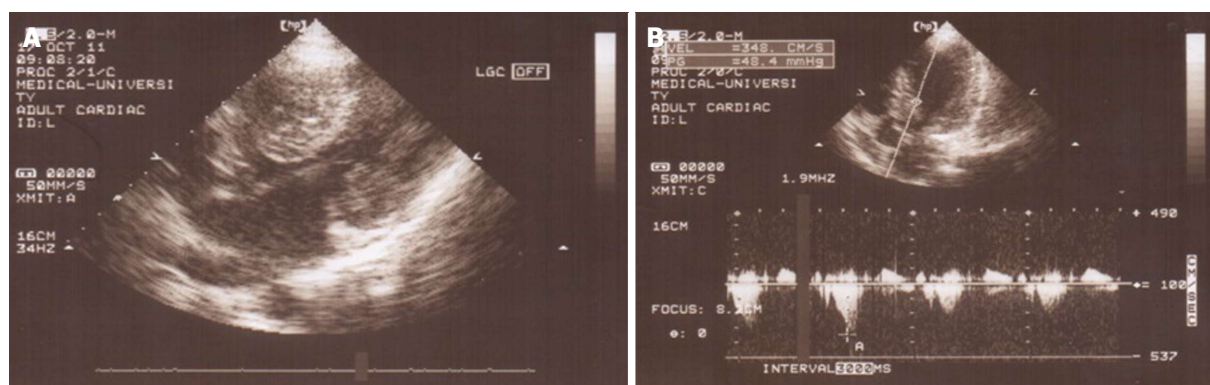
Patient with hypertrophic cardiomyopathy and subaortic stenosis. A: Parasternal long axis view showing expressed left ventricular (LV) hypertrophy at the region of the LV outflow tract; B: Doppler echocardiogram reveals the high subaortic gradient ($\Delta P = 48$ mmHg).
